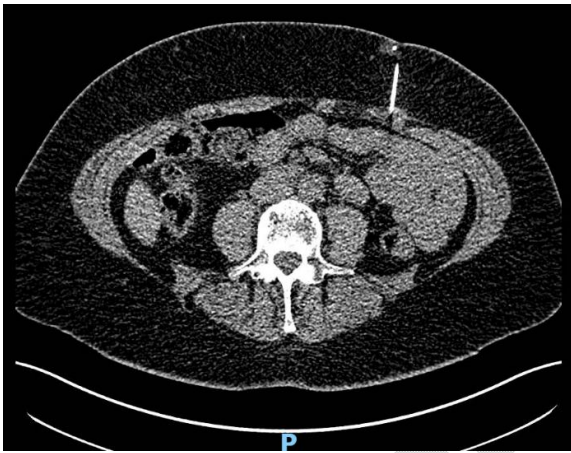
Axial CT marking left rectus sheath nodule
